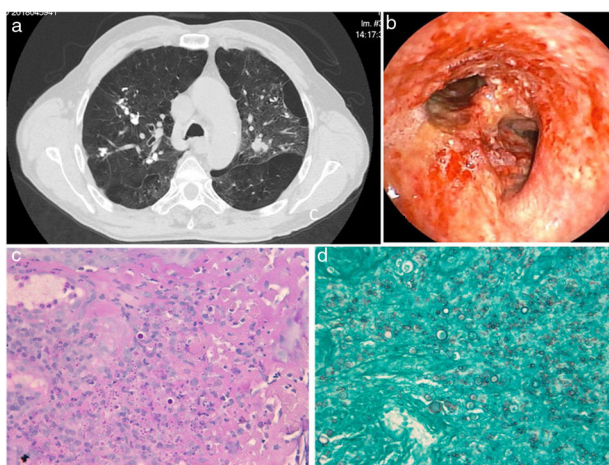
Computed tomographic image of the patient thorax (a) and endobronchial aspects of disease at the distal third of patient's trachea (b); Histochemical detection of fungal forms in PAS coloration (c) and Grocott coloration (d).
